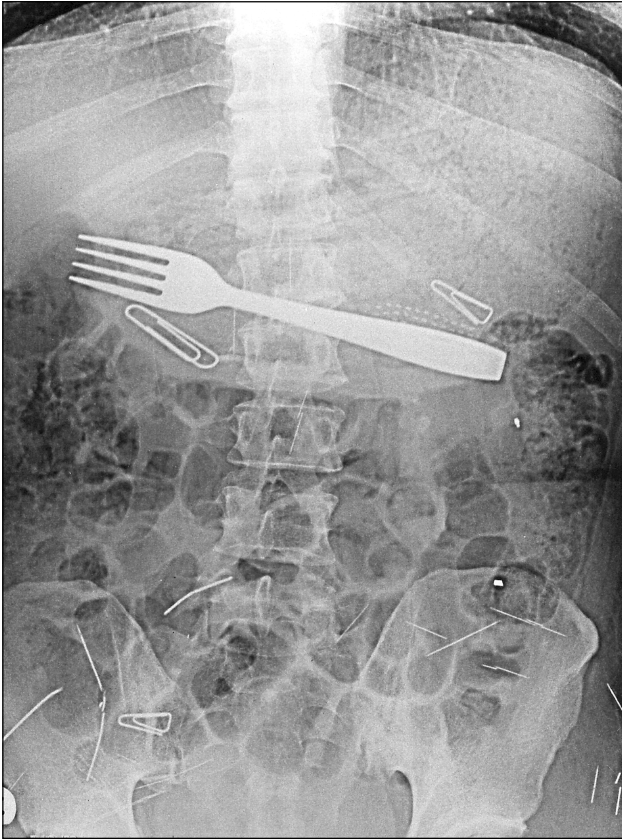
Abdominal X-ray showing ingested dinner fork (18 x 2.5 cm) and toothbrush
